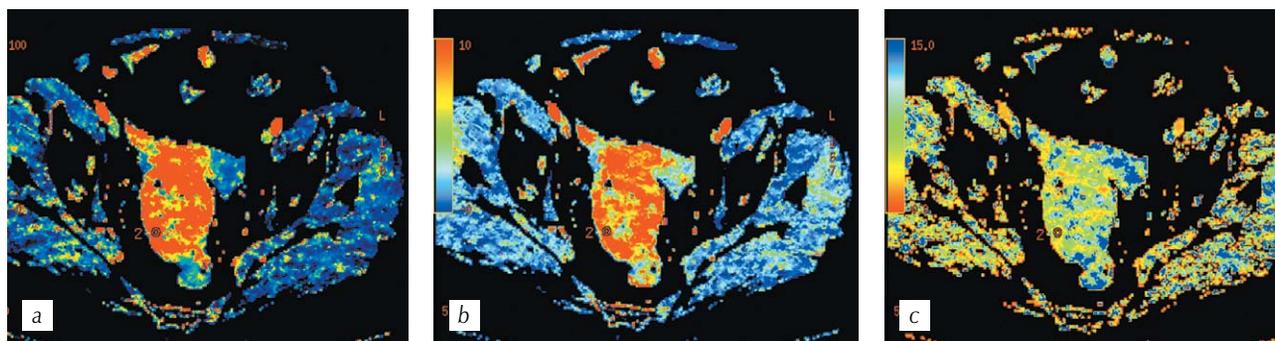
CT perfusion. Parametric maps: *a* — blood volume; *b* — blood flow; *c* — mean transit time of contrast medium. Strong vascularization of the rectosigmoid junction tumor in ROI 2 area
